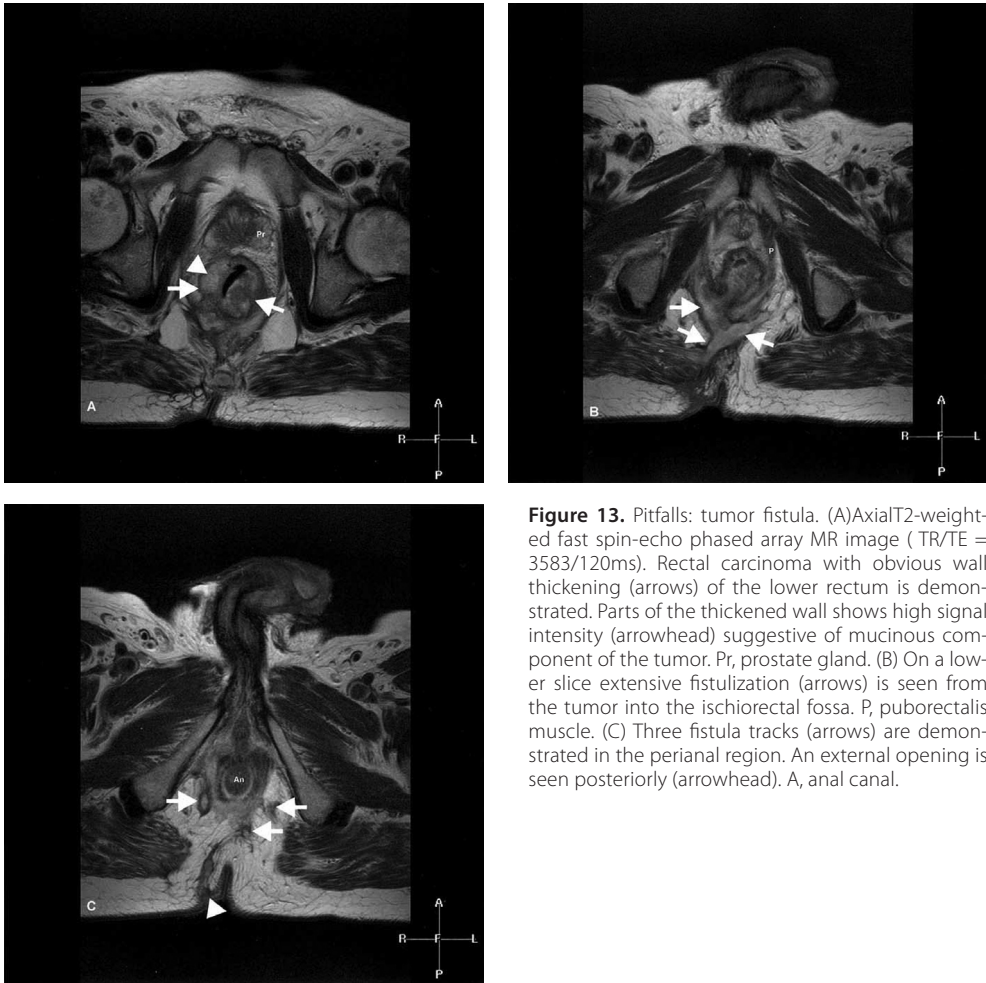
Pitfalls: tumor fistula. (A) Axial T2-weighted fast spin-echo phased array MR image (TR/TE = 3583/120ms). Rectal carcinoma with obvious wall thickening (arrows) of the lower rectum is demonstrated. Parts of the thickened wall shows high signal intensity (arrowhead) suggestive of mucinous component of the tumor. Pr, prostate gland. (B) On a lower slice extensive fistulization (arrows) is seen from the tumor into the ischioanal fossa. P, puborectalis muscle. (C) Three fistula tracks (arrows) are demonstrated in the perianal region. An external opening is seen posteriorly (arrowhead). A, anal canal.
